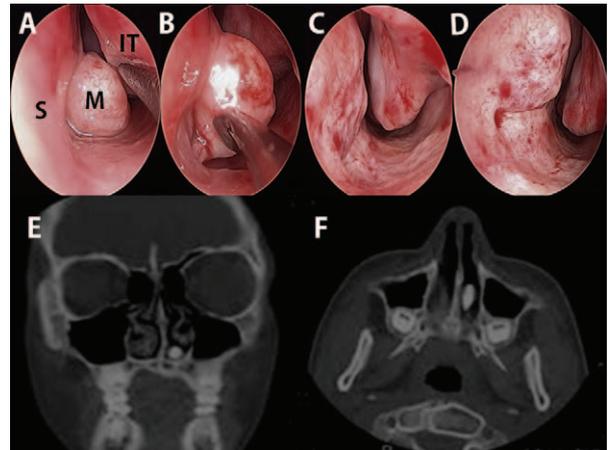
A and B, After the submucosal inferior turbinectomy and outfracture surgery to secure the space, nasal endoscopy revealed a nontender, hard, smooth, and movable mass located in the nasal floor between the nasal septum and the midportion of inferior turbinate (S, nasal septum; M, mass; IT, inferior turbinate). C and D, After the complete removal of intranasal tooth, we found that the tooth was fully erupting from the nasal septum and fully covered with the nasal mucosa but, not attached to the septum or the inferior turbinate. E and F, Paranasal sinus CT revealed normal bone continuity of facial skeleton with a radiopaque tooth-like structure on the nasal floor of left side located approximately halfway between the anterior and posterior portion of the naris. CT, Computed tomography.
